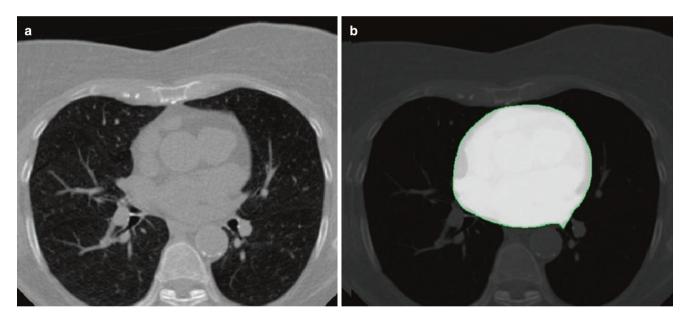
Segmentation of the heart. On the left (a) the input image and on the right (b) the binary segmented image projected over the original CT image [13]
